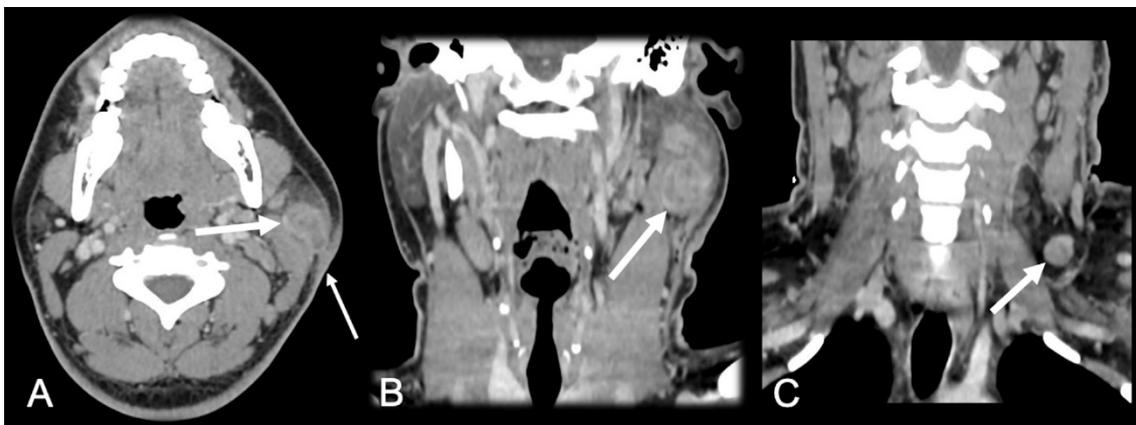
Primary parotid tuberculosis. Axial (A) and coronal (B) neck CT images showing an expansive lesion with heterogeneous enhancement and a central area of necrosis in the superficial lobe of the left parotid gland (thick arrow in A, arrow in B). The main parotid duct had a normal caliber. Sialolithiasis was absent. Also note the skin fistulization of the lesion (thin arrow in A). Cervical lymph node enlargement was present ipsilateral to the lesion, in the coronal plane (arrow in C).
